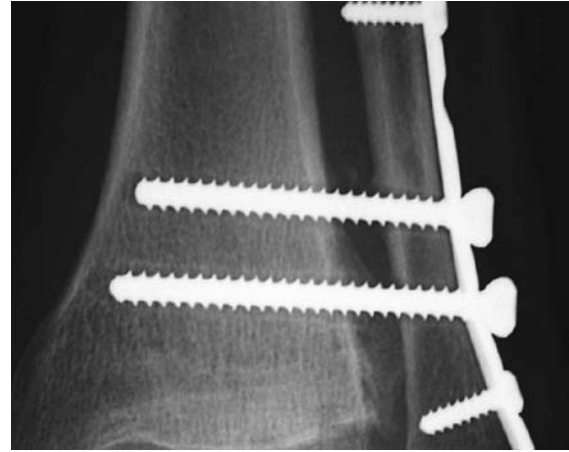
AP radiograph showing same effect.
